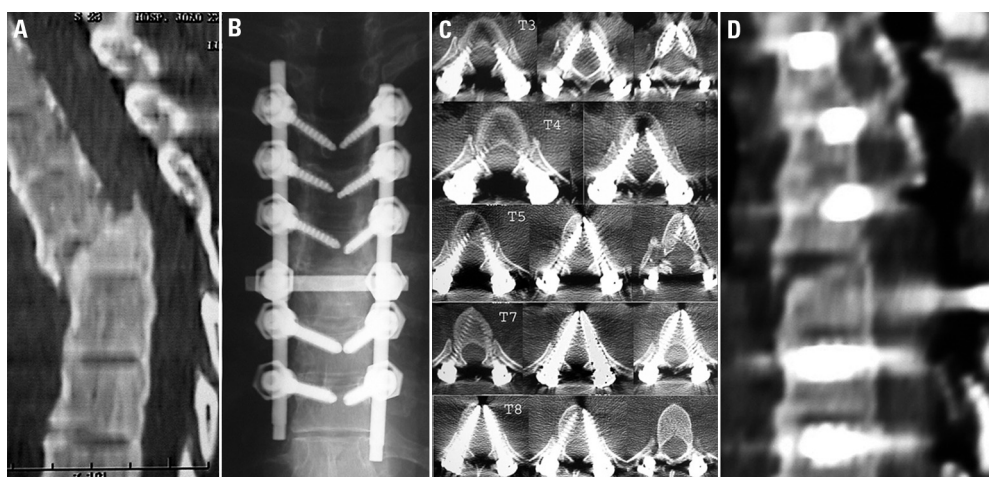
Images of patient # 6: a 50-year-old female collided her motorcycle against a deer and was admitted paraplegic. [A] Preoperative CT scan showing a T5-T6 fracture-dislocation with marked anterolisthesis and kyphotic deformity. [B] Postoperative X ray showing good coronal alignment and good screw positioning. [C] Postoperative CT scans confirming optimal placement of pedicle screws at all levels instrumented, from T3-T5 and T7-T8. [D] Postoperative CT scan showing complete reduction and restoration of normal sagittal alignment.
